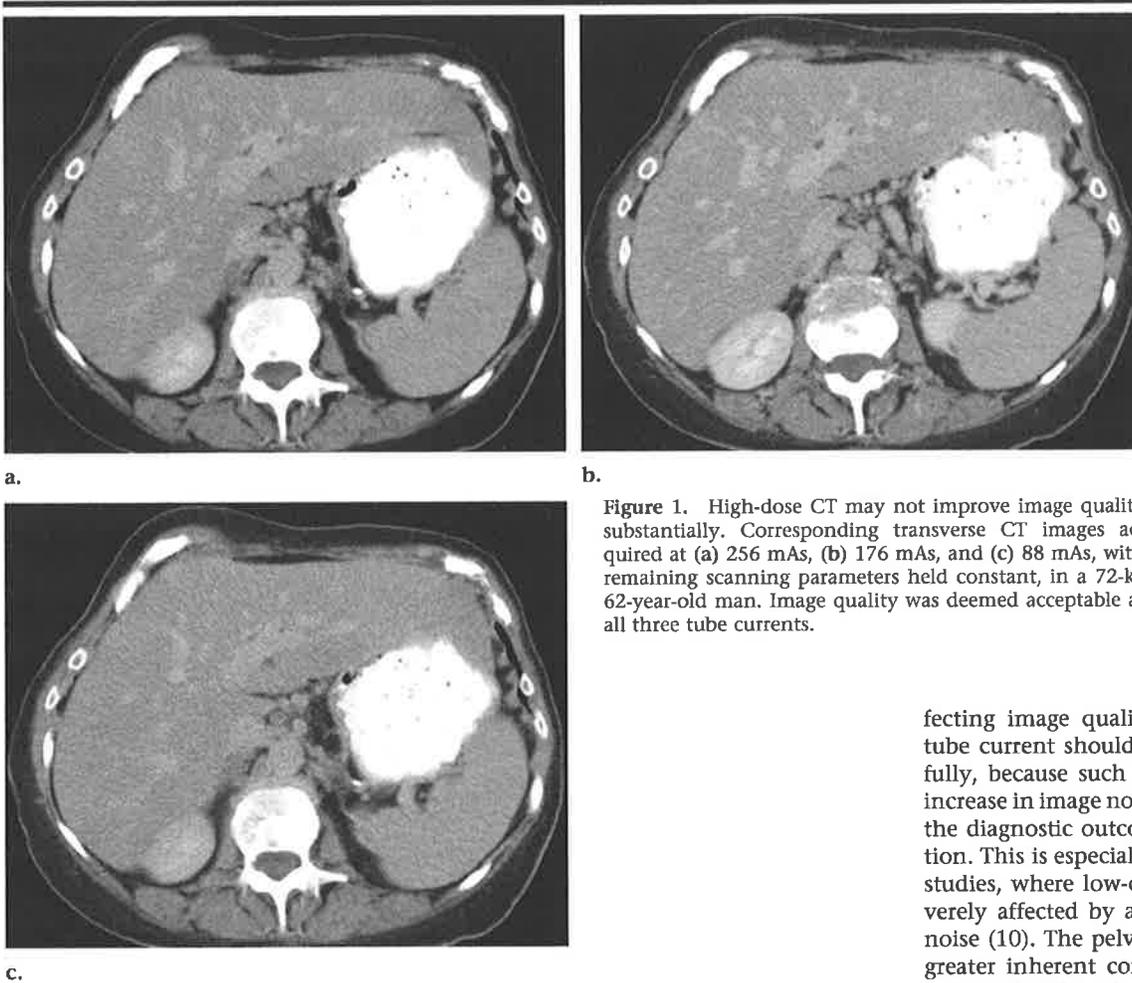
High-dose CT may not improve image quality substantially. Corresponding transverse CT images acquired at (a) 256 mAs, (b) 176 mAs, and (c) 88 mAs, with remaining scanning parameters held constant, in a 72-kg 62-year-old man. Image quality was deemed acceptable at all three tube currents.
